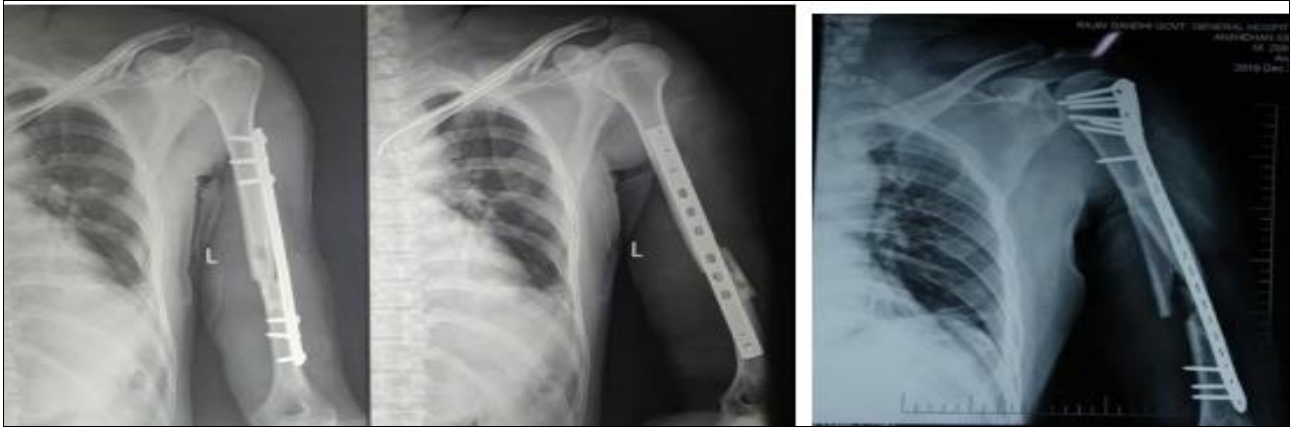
Immediate Post Op Xray
